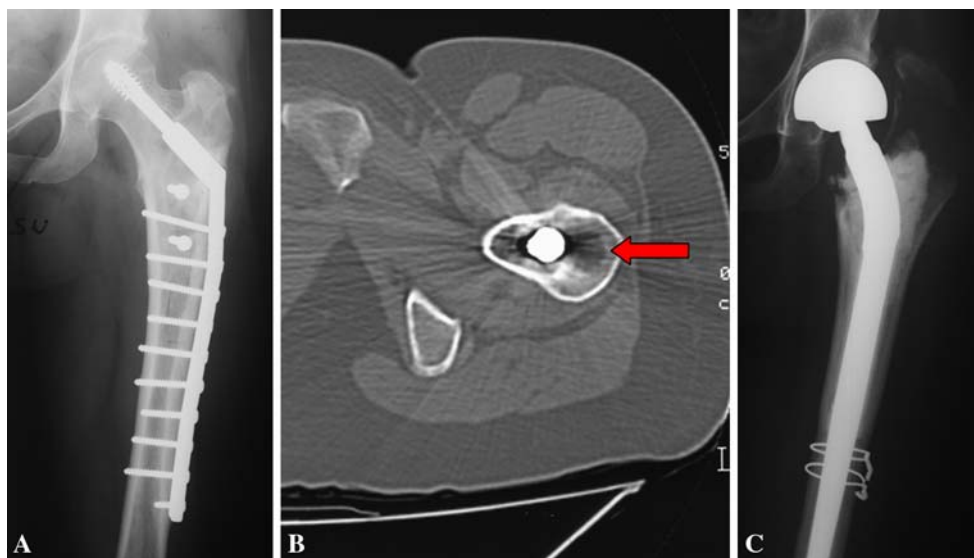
C (A) A local recurrence located in the greater trochanter is evident on this radiograph. (B) Although there were metal artifacts, CT confirmed the radiolucent area close to the bone fixation device
